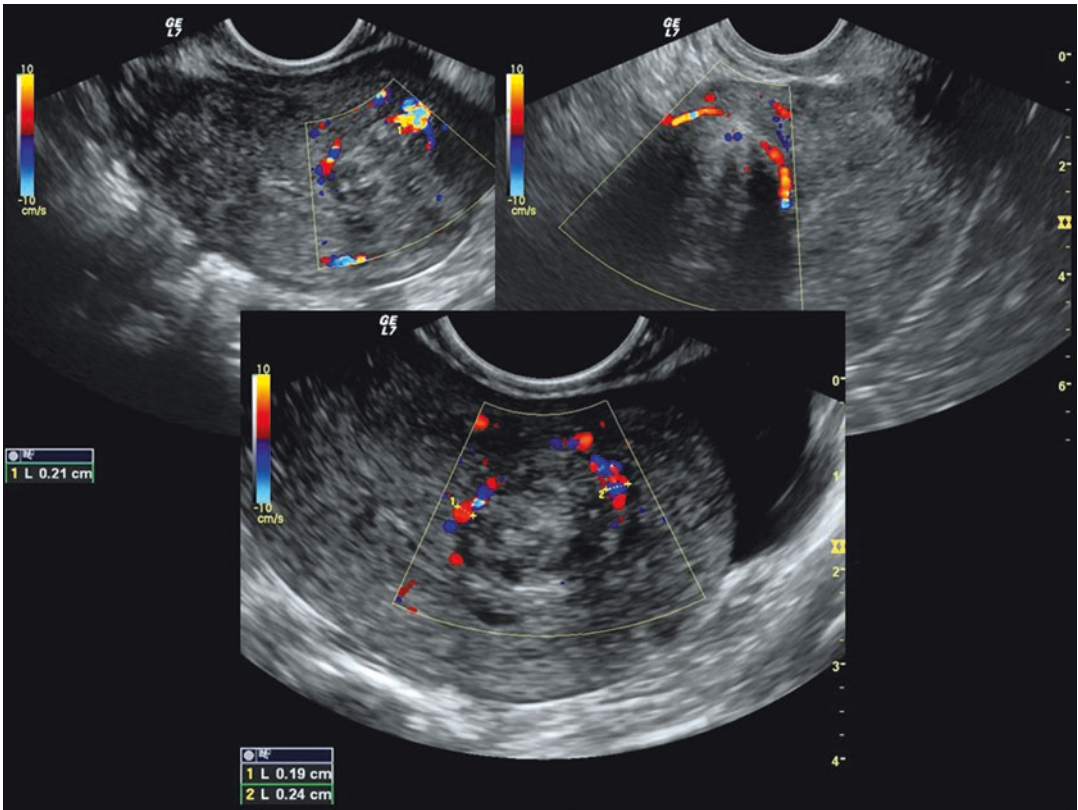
Ultrasonographic image of intracavitary fibroids, scanned by echo color Doppler, highlighting the “ring of fire,” with an intramural extension of 50% or more
